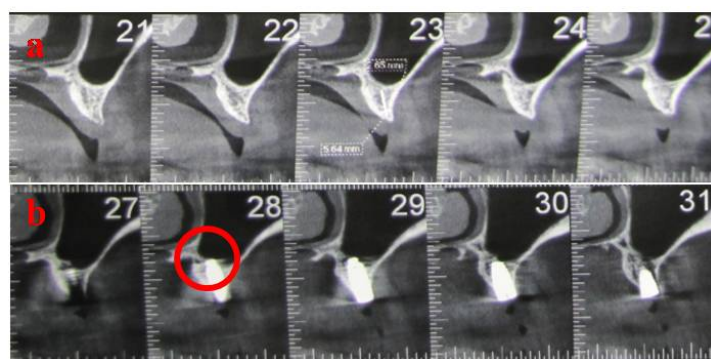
(a) Pre-operative CT scan (b) Post-operative CT scan
